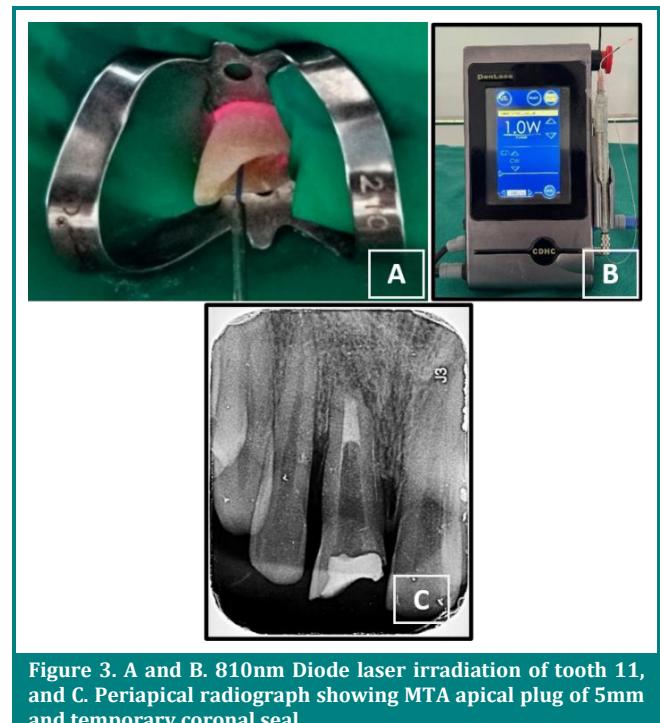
A and B. 810nm Diode laser irradiation of tooth 11, and C. Periapical radiograph showing MTA apical plug of 5mm and temporary coronal seal.
